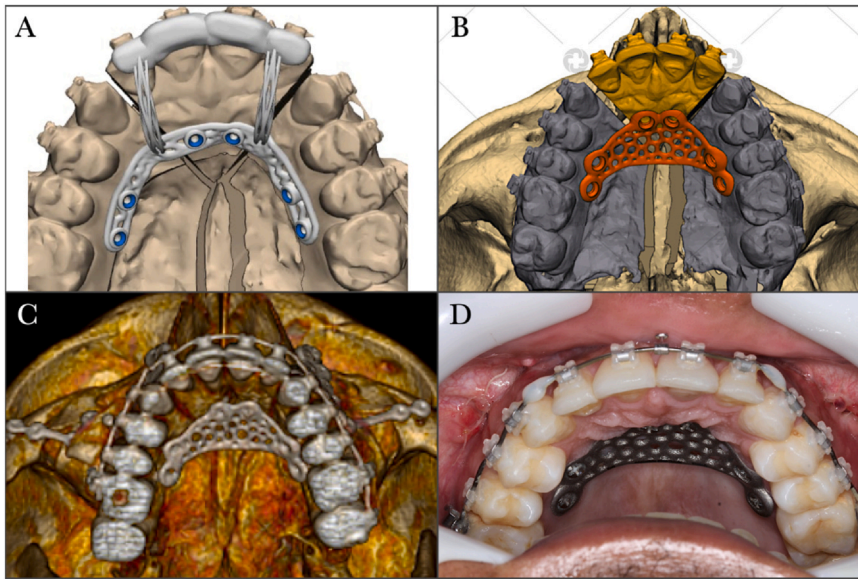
(A) The drilling guide design, with the maxillary segments in the preoperative position. (B) The customized palatal splint was designed after maxillary repositioning and expansion. (C) Postoperative CT scan. (D) Postoperative clinical aspect.
